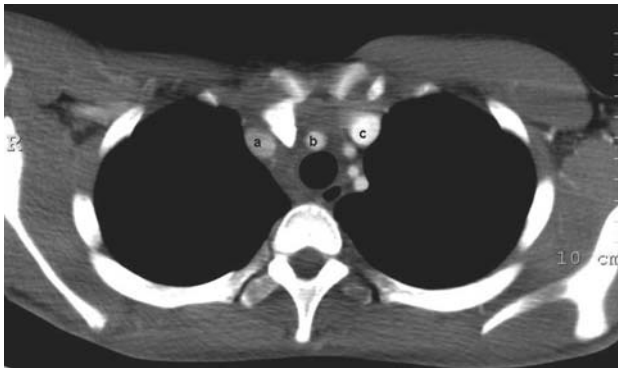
Plain CT scan of the SCJs, confirming the posterior dislocation of the right SCJ and its relationship to the major blood vessels. (a) Right brachiocephalic vein, (b) brachiocephalic artery, (c) left brachiocephalic vein.
